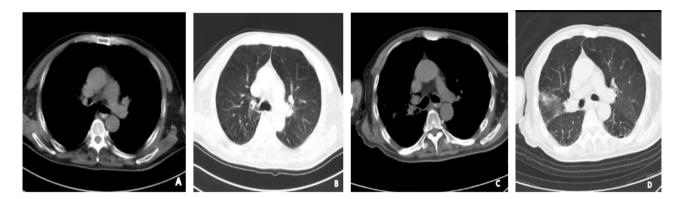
(A&B): Upon the patient's initial admission, a CT scan revealed bronchitis, emphysema, right upper lobe consolidation, and multiple nodules in both lungs. (C&D): At the time of discharge, a follow-up CT scan showed exudative lesions in the lower lobes of both lungs and localized atelectasis in the upper lobe of the right lung
